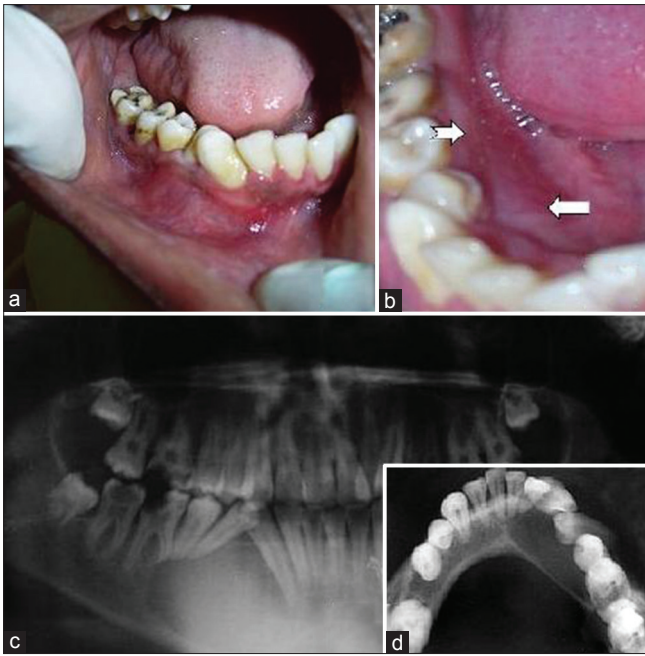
Intraoral photograph; (a) Buccal view; (b) Lingual view; (c) Panoramic radiograph showing radiolucent lesion in the right mandible with displacement and resorption of root apices of 44, 45 and mesial root of 46; (d) Mandibular occlusal radiograph showing expansion of buccal cortical plate
